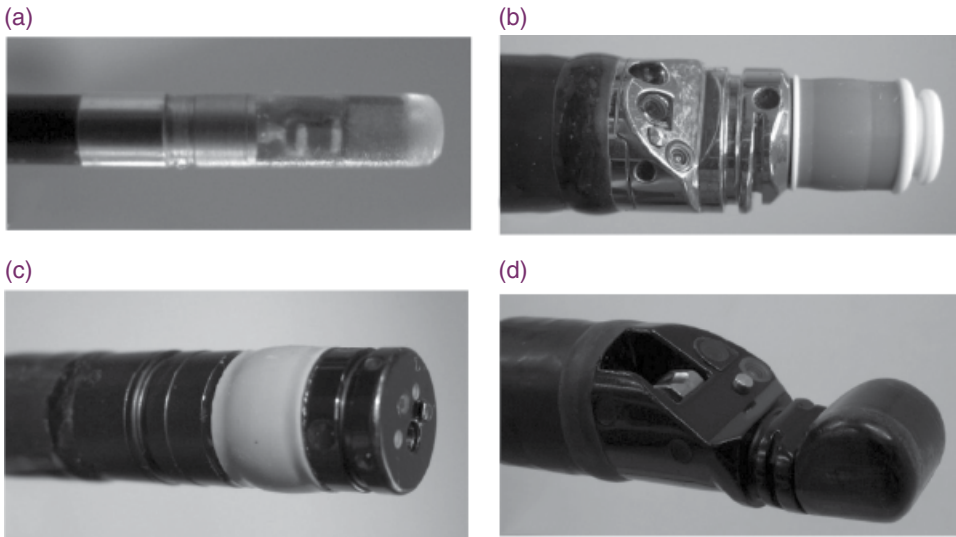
Endoscopic ultrasound (EUS) equipment with (a) a miniprobe 2.6 mm in diameter; (b) and (c) are 360° radial views, one with side viewing optics and the other with front viewing optics, respectively; and (d) the linear or fine needle aspiration EUS instrument.
